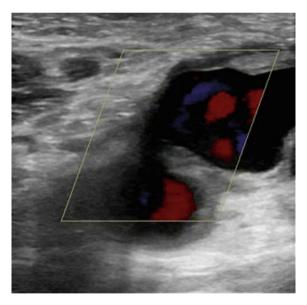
Duplex ultrasound image of the same lesion
